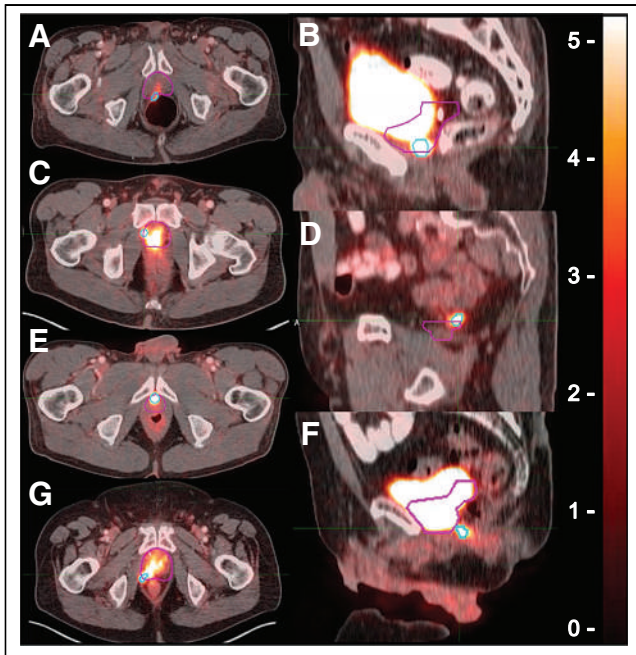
Definition of location of ^{68}Ga -PSMA PET lesion exceeding CTV borders. ^{68}Ga -PSMA PET contours are in light blue, and CTV contours are in pink. ^{68}Ga -PSMA PET lesion extended beyond CTV at posterior (A), inferior (B), lateral (C), superior (D), anterior (E), posteroinferior (F), and posterolateral (G) borders.
